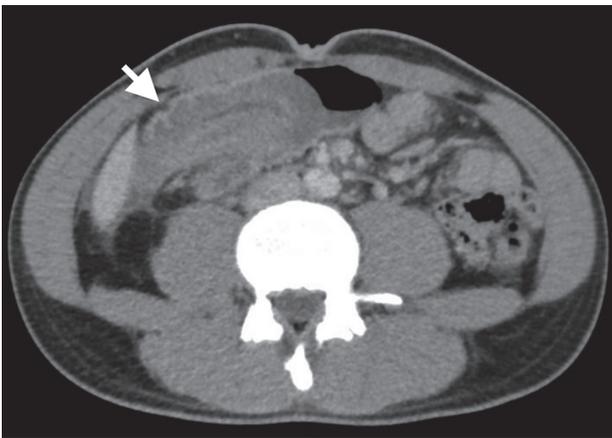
Computed tomography demonstrating a right-sided colocolic intussusception.
